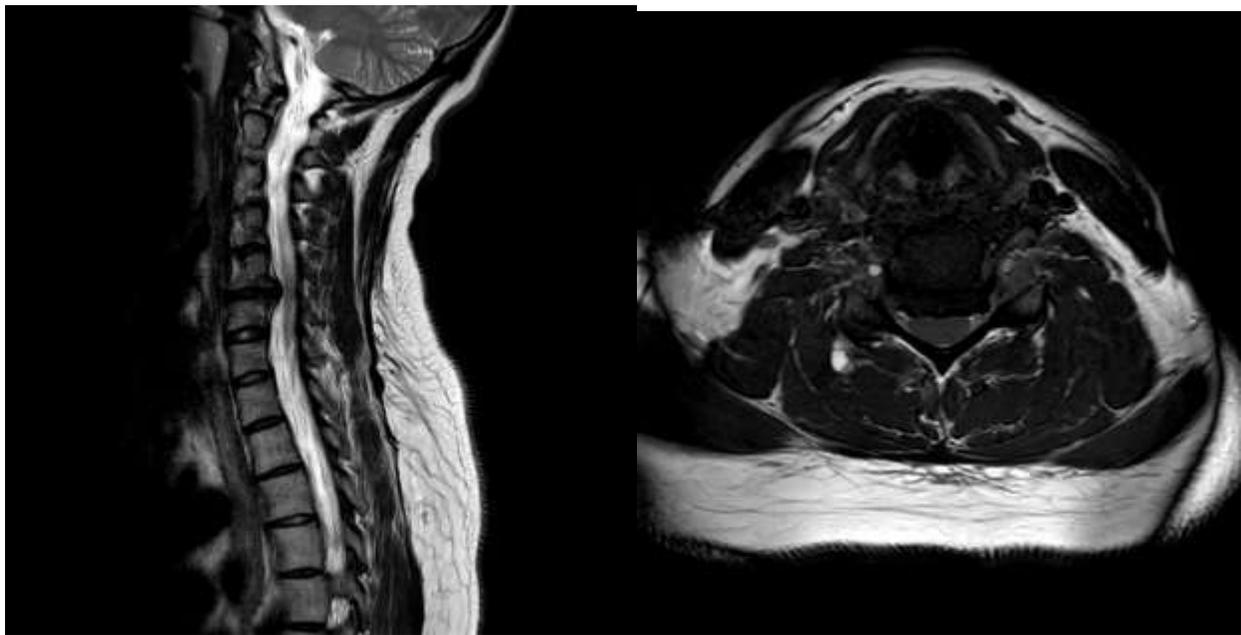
MRI before operation
